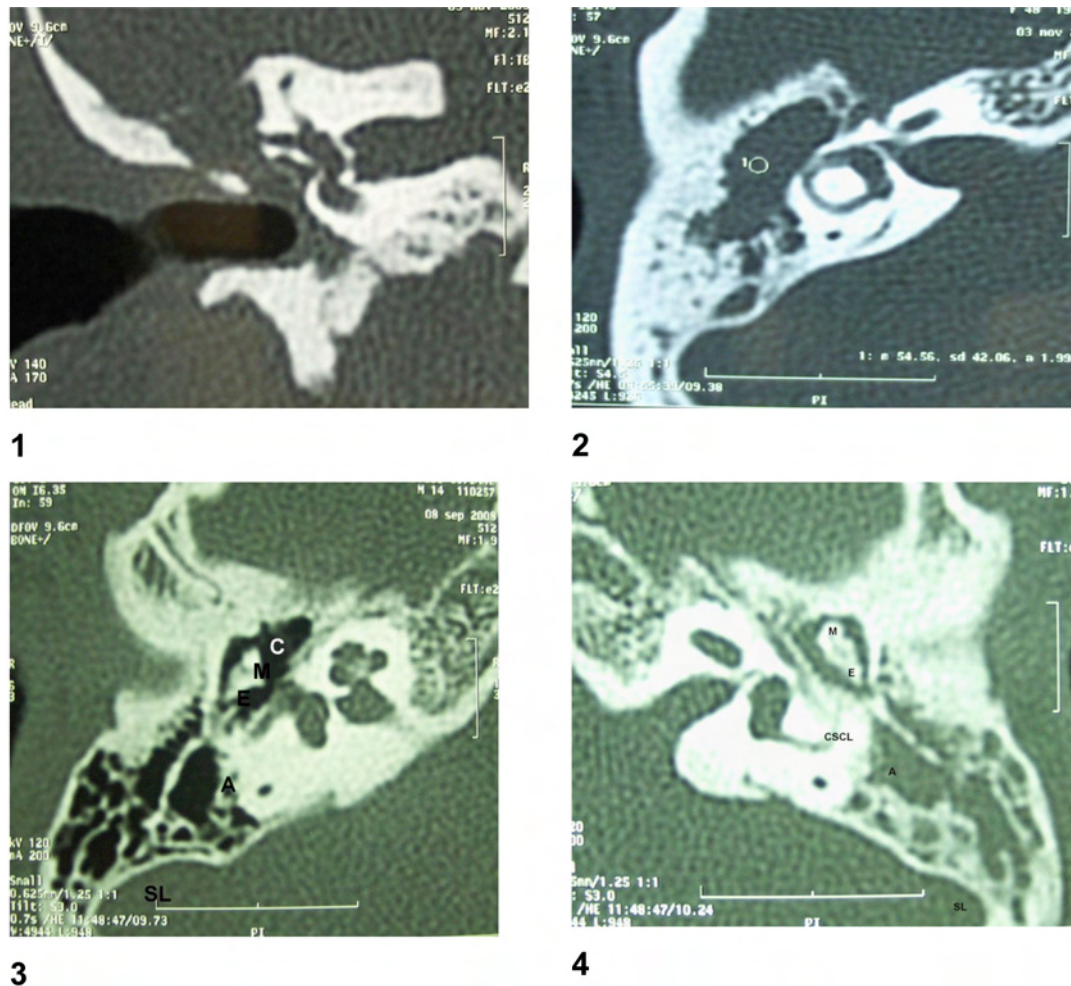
Some aspects of the different lesions observed CT. 1 and 2. Coronal and axial CT scan cut respectively, a right ear showing a cholesteatoma with extensive denudation of the lateral semicircular canal, the denudation of the meninges of the middle cerebral fossa. lysis of the scutum and the ossicles chain. Note also the denudation of the second portion of the facial canal. 3 and 4. CT of both ears of the same patient, we note the importance of pneumatization of both mastoids: right without cholesteatoma and left side with cholesteatoma, which was extended and digitiform at the operation. A: antrum; SL: Lateral sinus; CSCL: lateral semicircular canal; V: Vestibule; M: malleus; E: incus; C: tympanic cavity.
